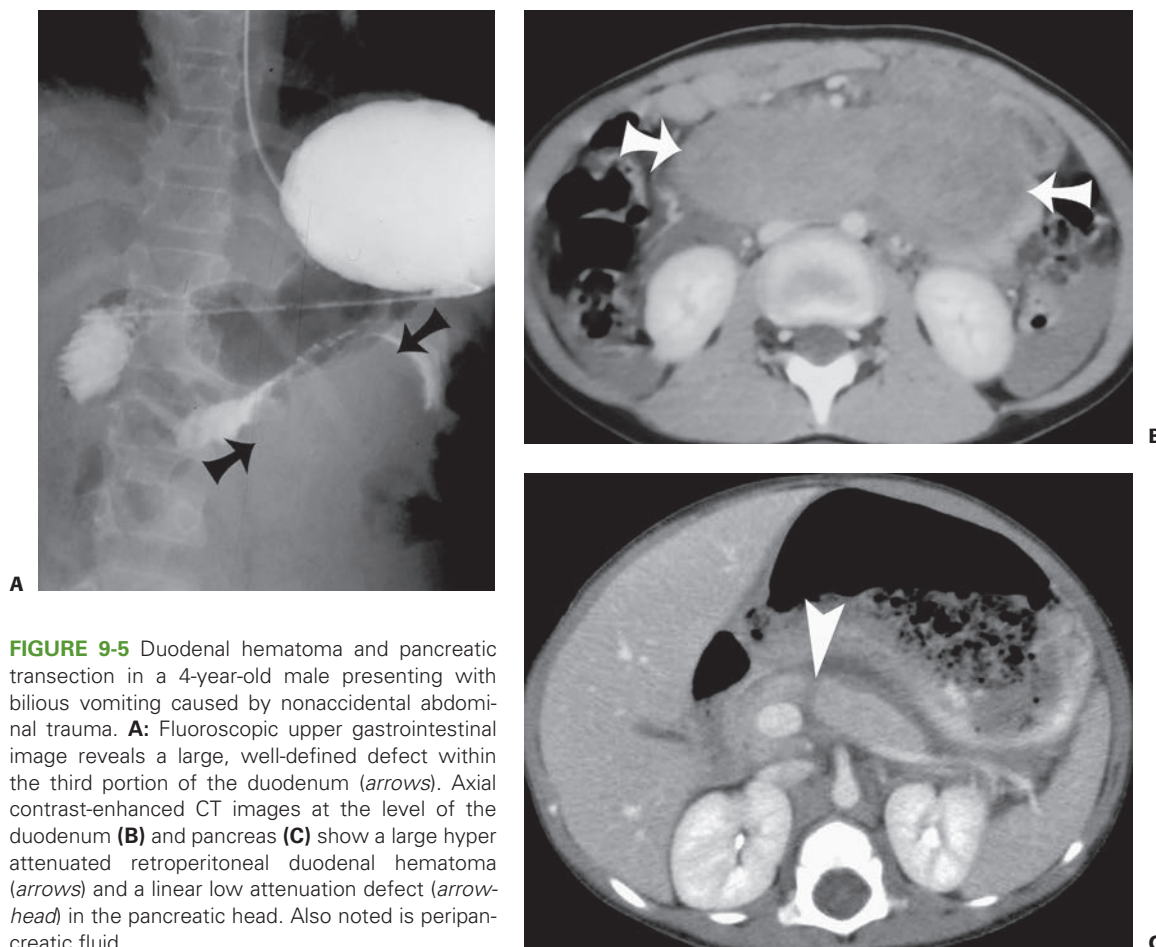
Duodenal hematoma and pancreatic transection in a 4-year-old male presenting with bilious vomiting caused by nonaccidental abdominal trauma. A: Fluoroscopic upper gastrointestinal image reveals a large, well-defined defect within the third portion of the duodenum (*arrows*). Axial contrast-enhanced CT images at the level of the duodenum (B) and pancreas (C) show a large hyperattenuated retroperitoneal duodenal hematoma (*arrows*) and a linear low attenuation defect (*arrowhead*) in the pancreatic head. Also noted is peripancreatic fluid.
